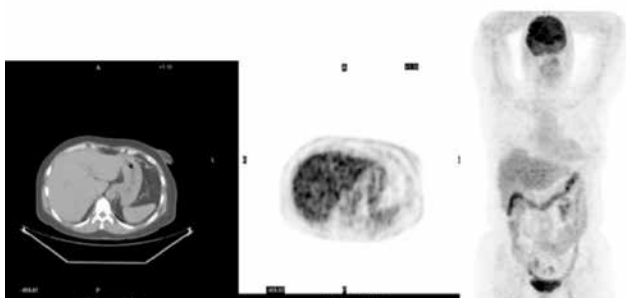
Axial computed tomography, PET and whole body maximum intensity projection ^{18}F -FDG positron emission tomography/computed tomography images of the patient. There was no pathological uptake in the stomach or entire body
